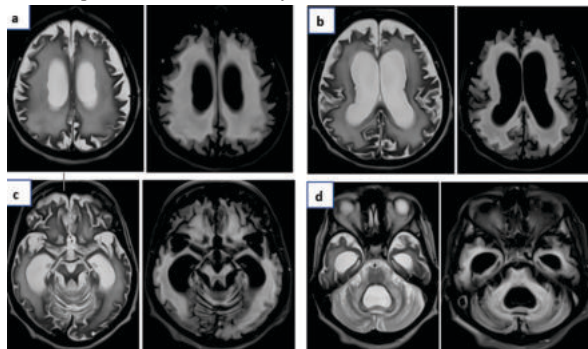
a), b), c) and d) T2W/FLAIR axial sections show diffuse cerebral and cerebellar atrophy with ex-vacuo dilatation of ventricles. Mid-brain atrophy with prominent cerebral and cerebellar peduncles.
